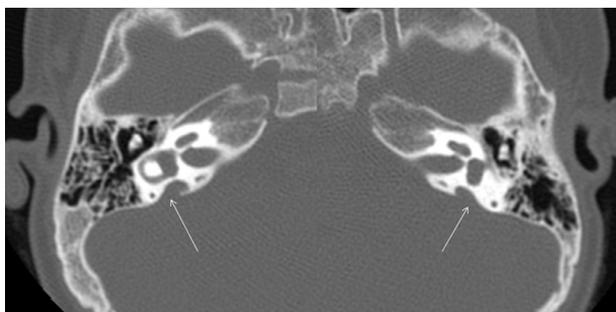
Bilateral EVA. Axial CT images demonstrate bilateral EVA's which can create a pathologic third window. (arrows).
